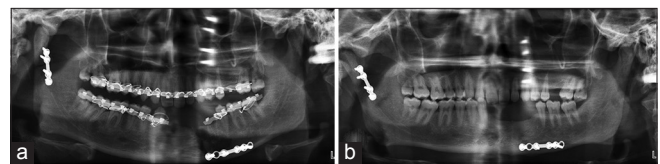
(a) Immediate postoperative orthopantomogram showing good anatomical reduction of mandibular condyle fracture. (b) Eight months postoperative orthopantomogram showing stable position of condylar head
